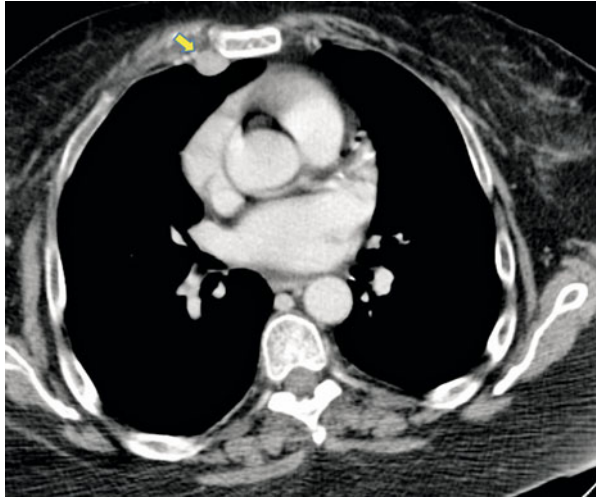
Axial CT image shows enlarged right pericardial lymph node (*arrow*) in a patient with ovarian cancer
